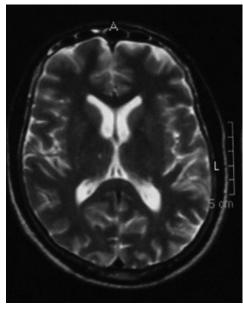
Conventional MRI of the Case 1. Infarctions in both cerebellar hemispheres, in the right caudate nucleus and left thalamus
